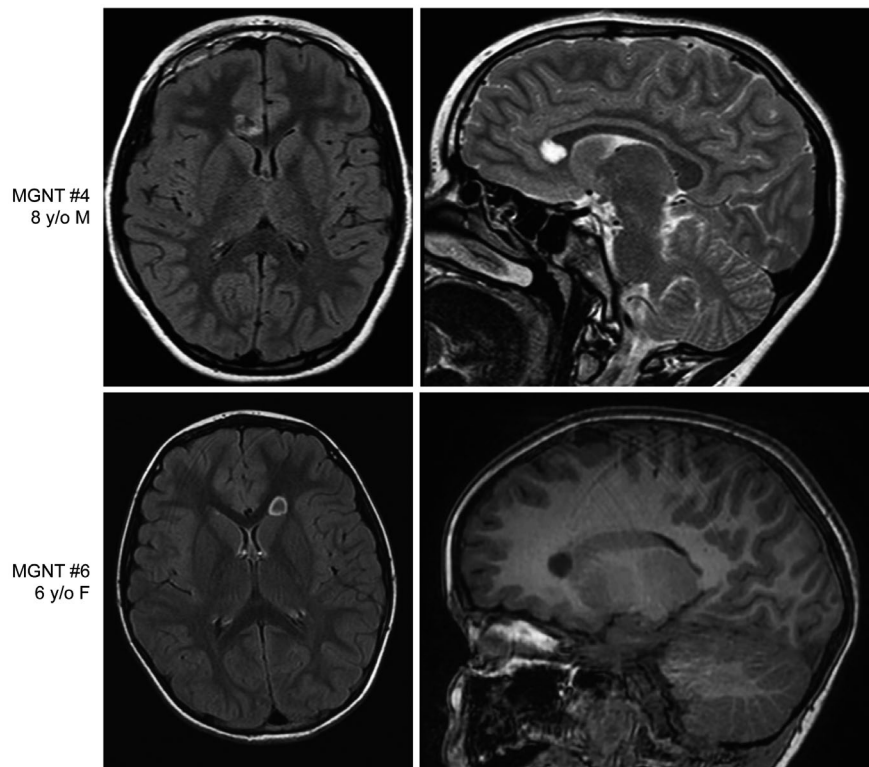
Myxoid glioneuronal tumor, PDGFRA p.K385-mutant, can also arise in the corpus callosum, in addition to its stereotypic location in the septum pellucidum. Pre-operative magnetic resonance images for patients MGNT #4 (8-year-old male) and MGNT #6 (6-year-old female) showing a well-circumscribed, T2/FLAIR-hyperintense mass lesion centered in the genu of the corpus callosum.
